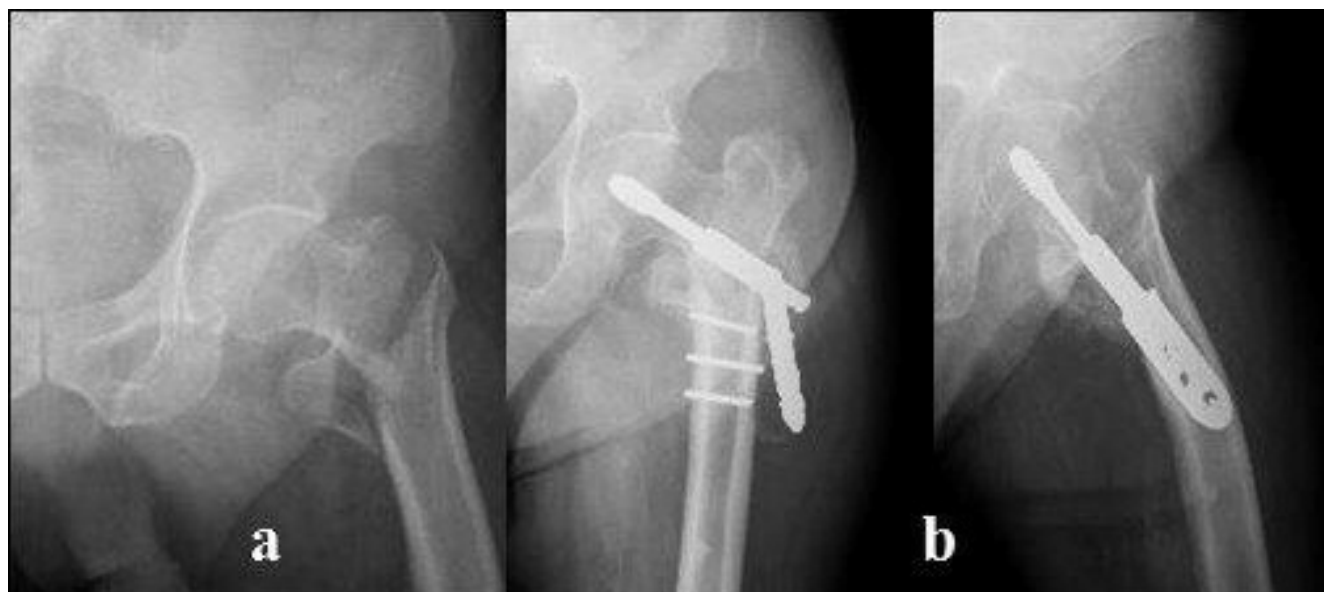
Preoperative X-rays of a 80-year-old patient with a 31.A2 trochanteric fracture treated by DHS (a). Three months after surgery: screws breakage and varus deformity (b).
